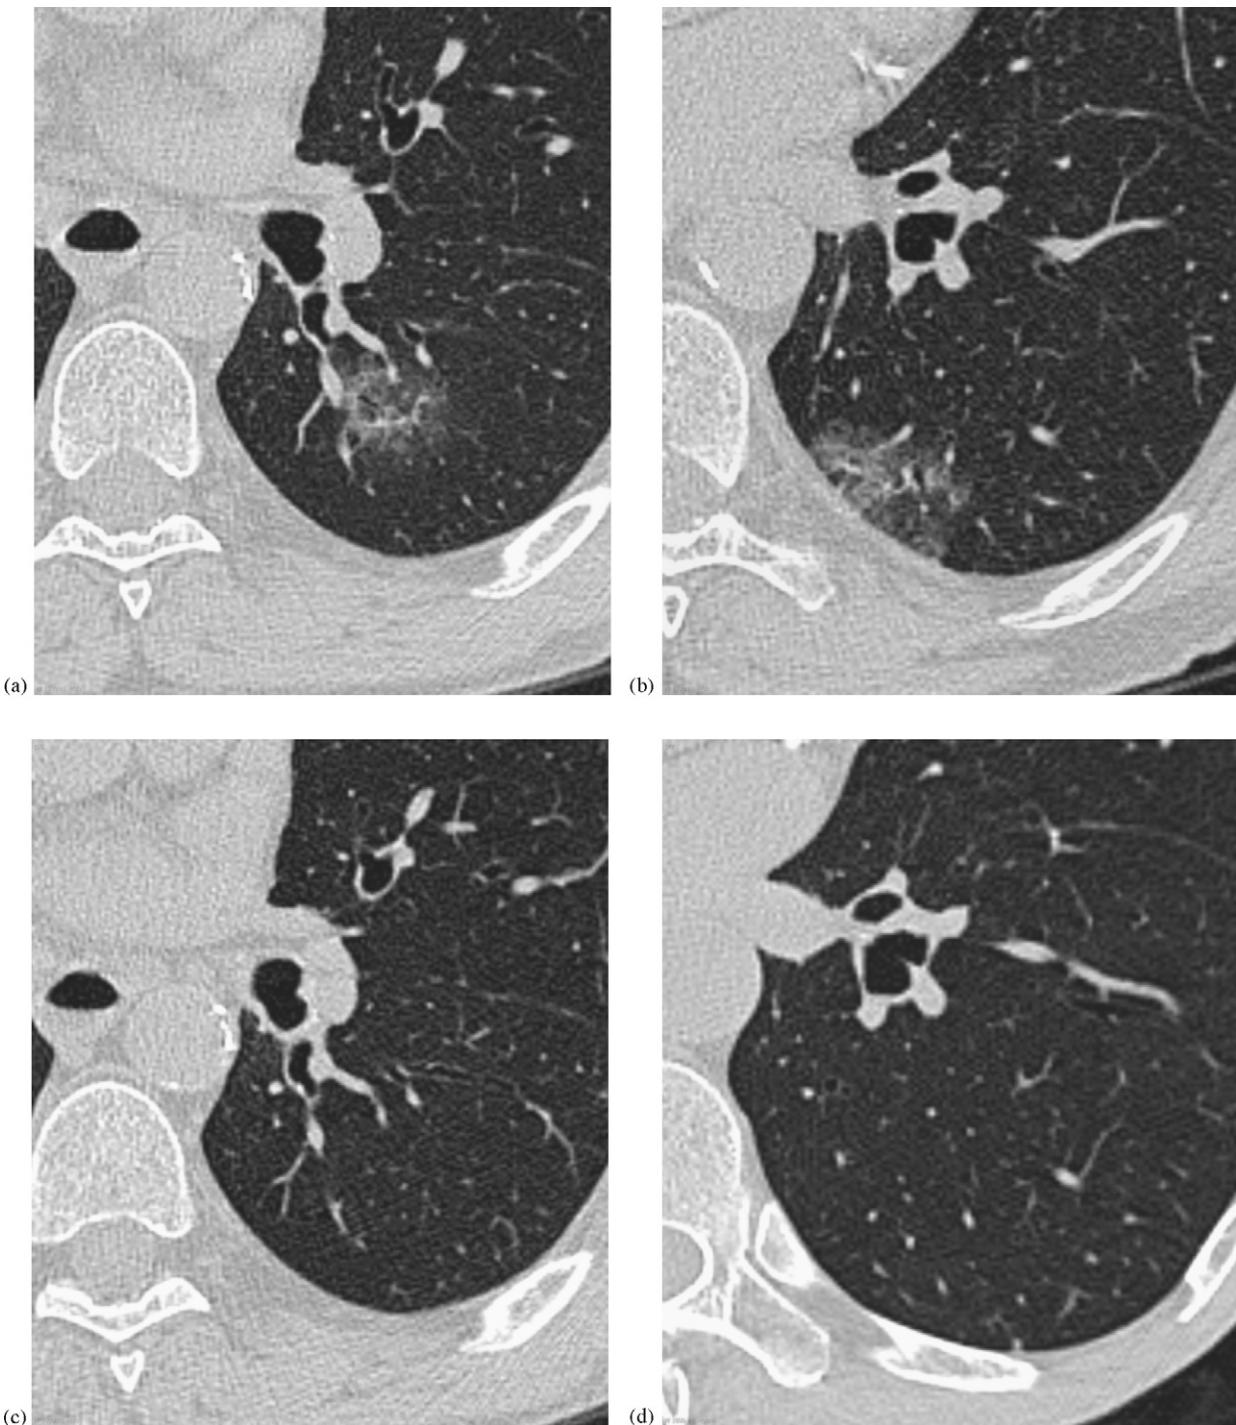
A 67-year-old man with a history of cigarette smoking and head and neck cancer. (a and b) Transverse high-resolution CT scan shows two localized ground-glass opacities in the left lower lobe: a 23-mm round pure ground-glass opacity (a) and a 26.5-mm polygonal pure ground-glass opacity (b). (c and d) The two lesions are completely resolved on follow-up CT scan 2 months later.
